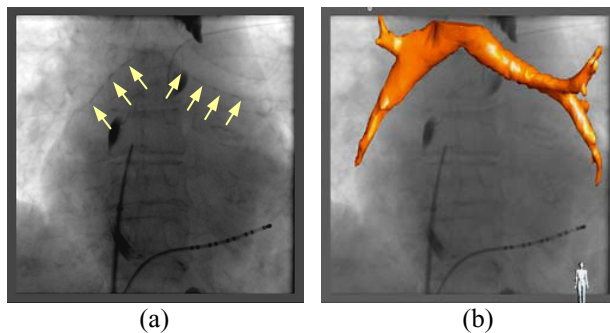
(a) An X-ray image showing the tracheal bifurcation. (b) A 3D model of the tracheal bifurcation derived from CT data is overlaid on to the X-ray fluoroscopic image.
